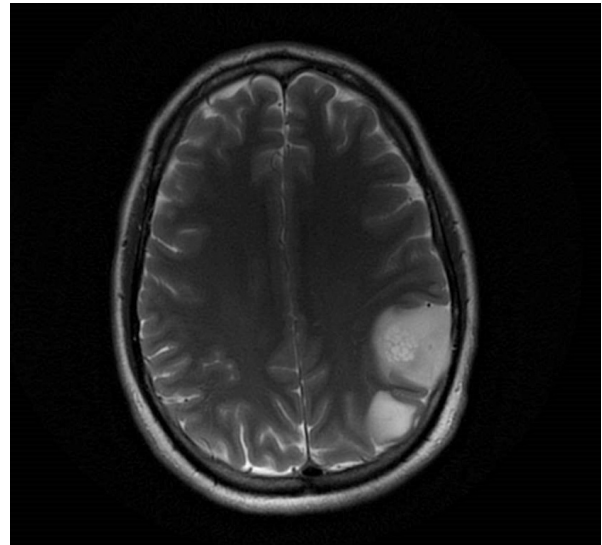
Preoperative Magnetic Resonance Imaging, axial sequence in T2. In all the sequences and projections, 2 close but completely separated lesions were observed.
